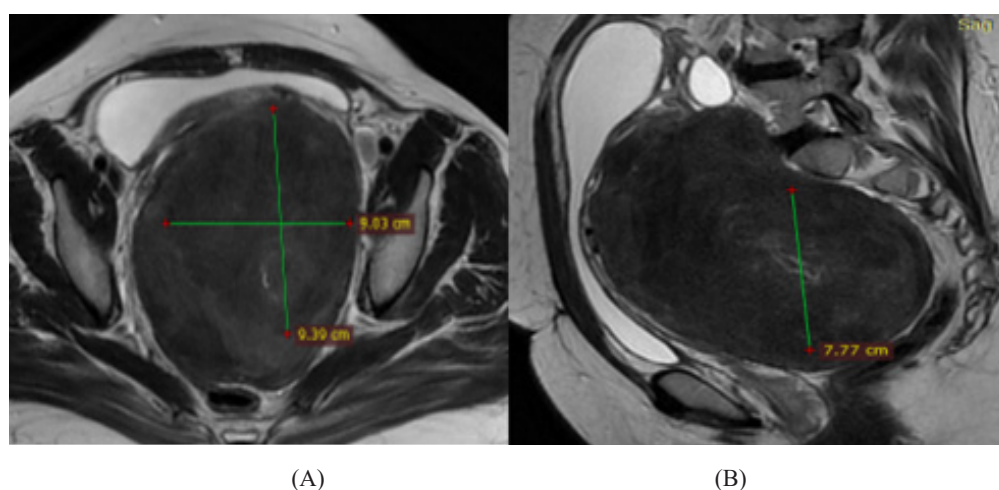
A 40-year-old female presented with lower back pain, pelvic heaviness, constipation, and frequent urination. She underwent one MR-HIFU session, and now the patient has reported a significant relief of the symptoms. Axial (A) & Sagittal (B) T2 MRI images demonstrate a large posterior wall interstitial myoma, showing dark signal denoting FUNAKI-type I. Total myoma volume before HIFU = 335 cc.
